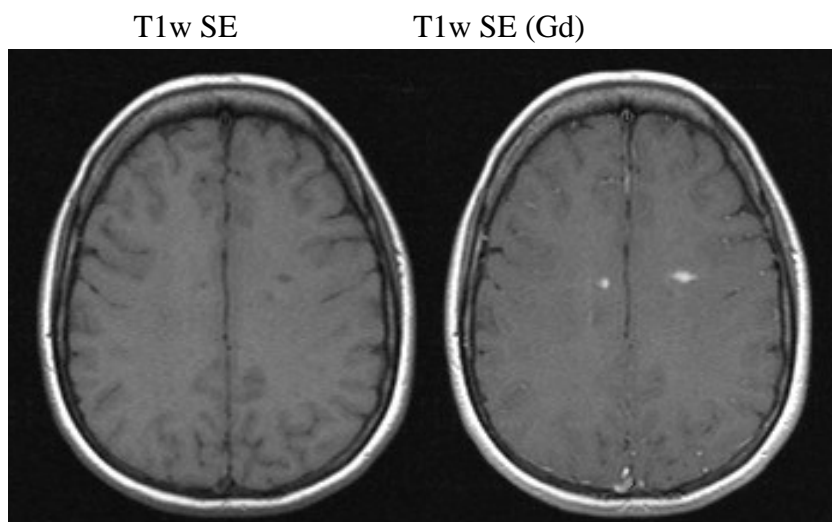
Example of clinical standard MRI used for monitoring MS. left: T1-weighted spin echo image; right: T1w-SE image with Gd-enhancement.
